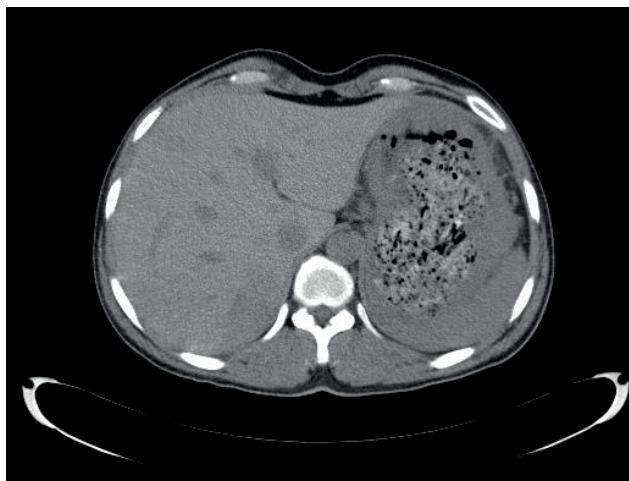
CT thickening of the fundus and corpus wall, up to 2.7 cm.
